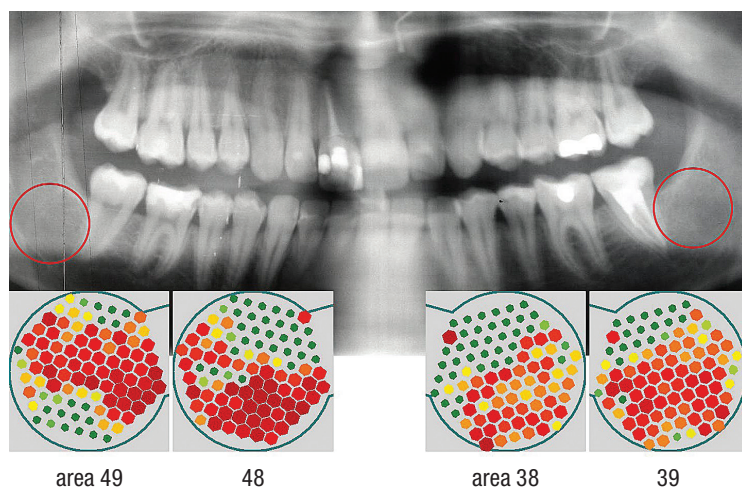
Inconspicuous dental panoramic tomogram from December 2009 with no radiological abnormalities in the areas of the surgically removed teeth #18, 28, 38 and 48. The lower line shows the through-transmission alveolar ultrasonography scan; green corresponds to firm, that is, healthy jawbone; red indicates softened jawbone with inflammation potential.
